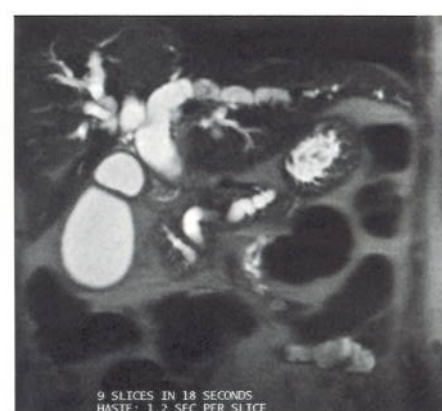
Variable matrix HASTE technique for breathhold T2-weighted abdomens and spines.
